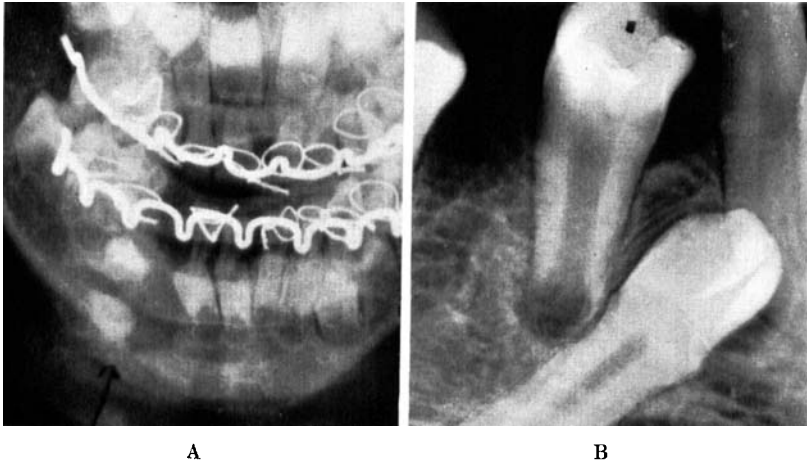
Case no. 2. ♂ aged 14 years. Fracture of the mandible (regio 3—) when the patient was 5 years of age. A shows the state 5 days after the fracture. B is a radiograph 9 years after the fracture. Note the embedded and dislocated 3—, which also shows slight dilaceration. A section of the same tooth is seen in fig. 9.
